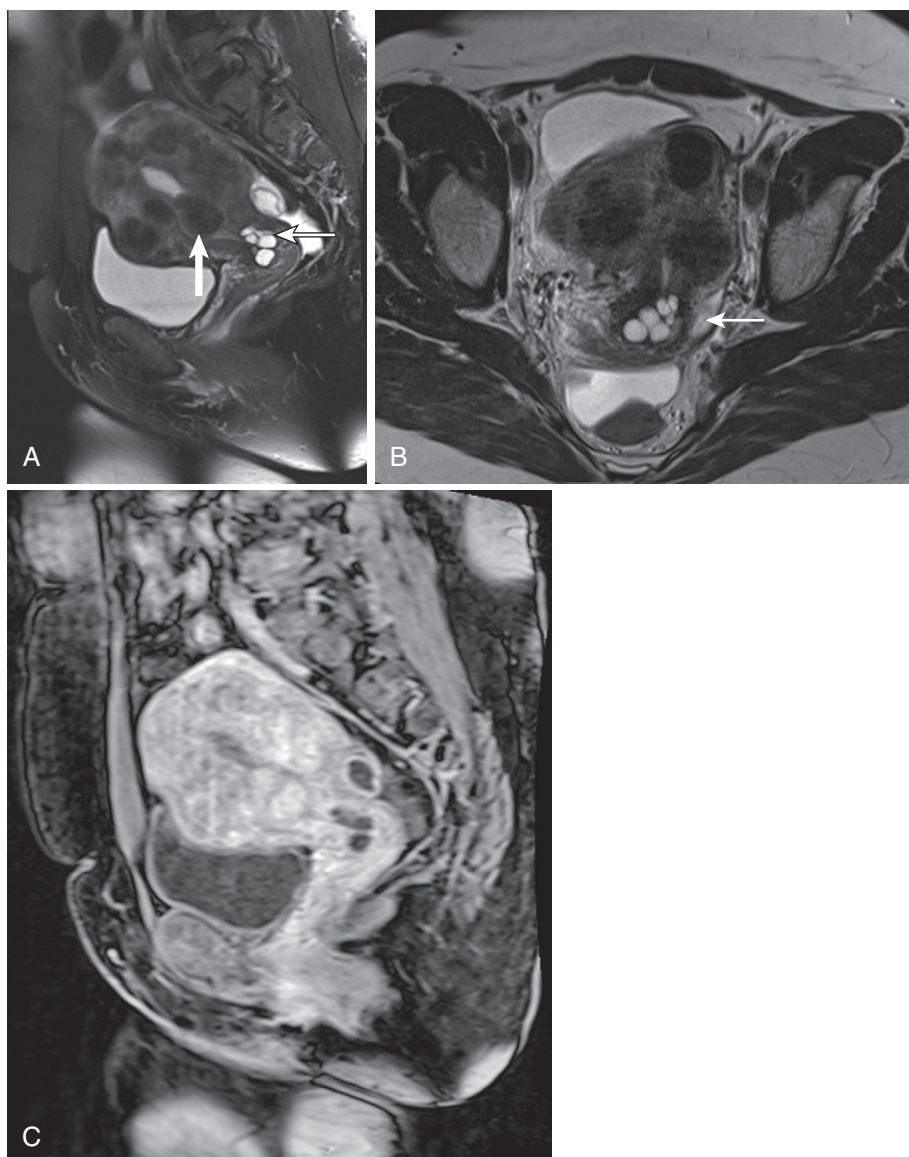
Nabothian cysts. Sagittal T2-weighted fat-saturated (A) and axial T2-weighted (B) images show a cluster of simple Nabothian cysts (*thin arrow* in A and B) apposed to the endocervical canal in a patient with multiple fibroids, including a submucosal fibroid (*thick arrow* in A). C, Sagittal enhanced T1-weighted fat-saturated image confirms an absence of enhancement.
